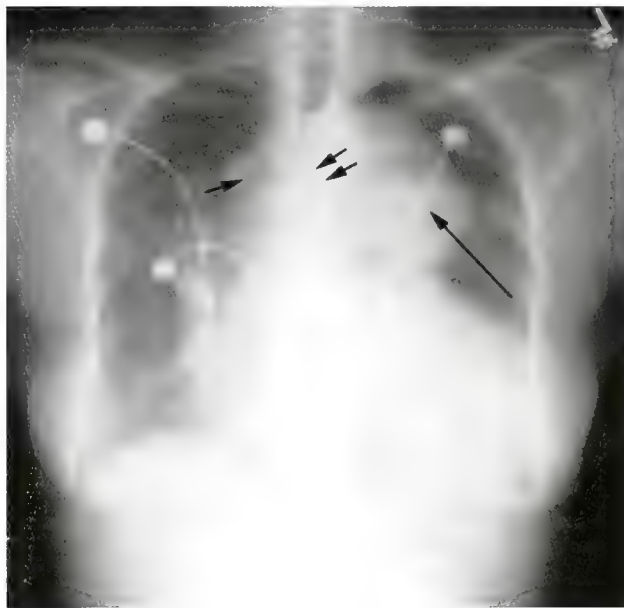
Chest radiograph showing a massively dilated left pulmonary artery (long arrow). Narrowing of the trachea is evident just above the carina (paired arrows). The aortic knob can be seen arising to the right of the trachea (short arrow).
